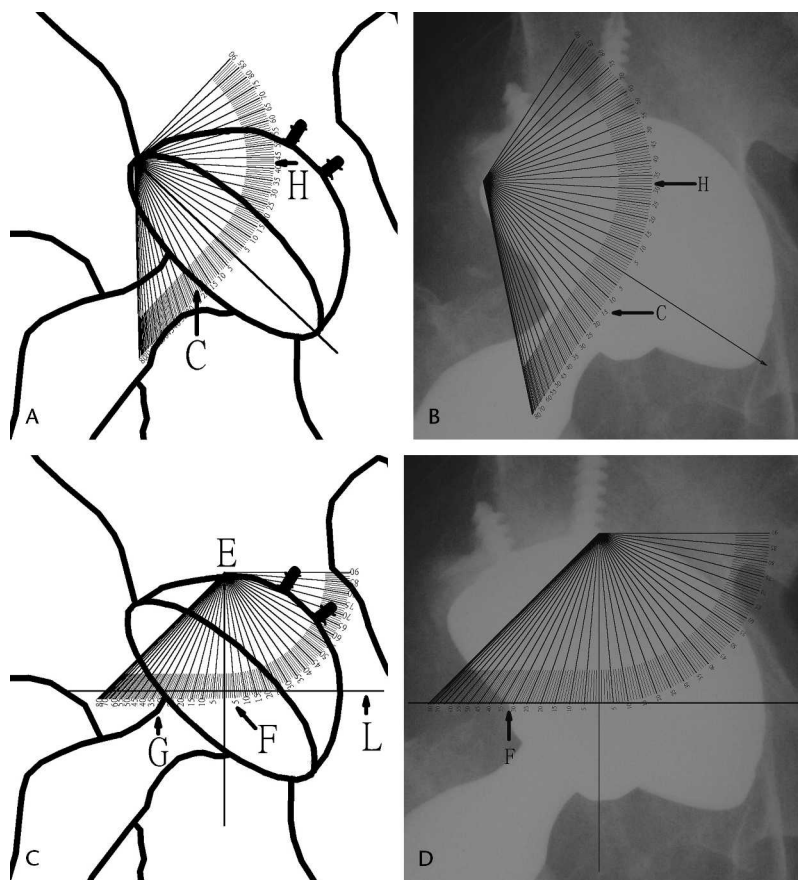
(A) We estimated Point C (arrow) to determine a 20° planar anteversion angle. The horizontal line of the pelvis (parallel to the line passing through both teardrop landmarks) (arrow H) was 41°, which determined the abduction angle. (B) The protractor was used with a real radiograph. It shows a planar anteversion angle of 16° and an abduction angle of 32°. (C) The base-line of the protractor was aligned with point E (the top-most point of the semicircle) and point F (the center of the ellipse). We determined point G by the intersection of the horizontal line L passing through point F. The true version angle was 34° as measured by point G. (D) The anteversion angle was 32° when using the protractor with a real radiograph.
